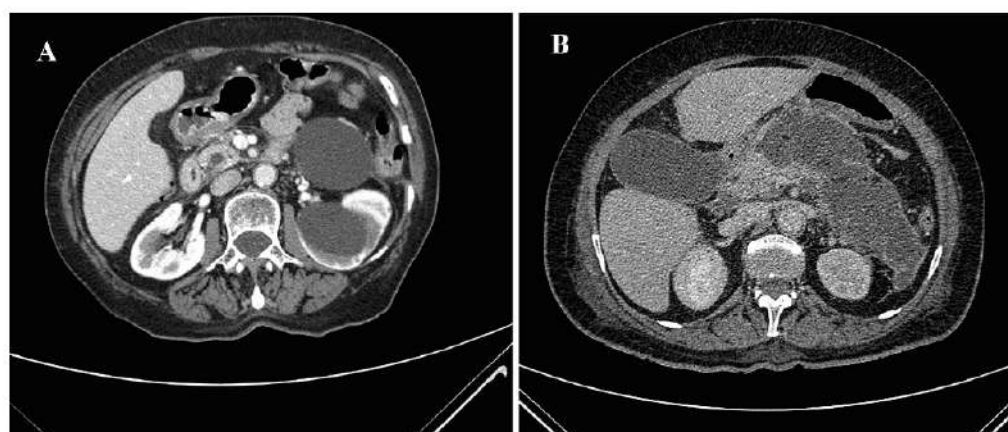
CT scan images of two patients with walled-off pancreatic necrosis. Image A reveals a low content of necrosis, characterized by a collection with regular and well-defined margins and content
